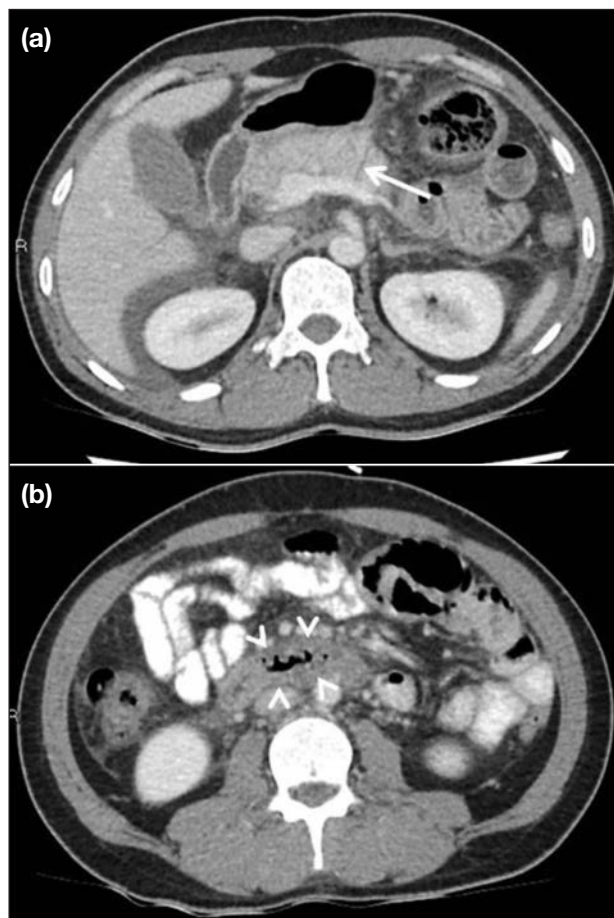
(a) Contrast-enhanced axial computed tomography scan image 2 days after initial presentation shows linear hypodensity traversing the width of the pancreatic body suspicious for transection (white arrow). (b) Contrast-enhanced axial computed tomography scan image 2 days after initial presentation shows marked mural oedema of the third part of the duodenum suspicious for contusion (white arrowheads).
